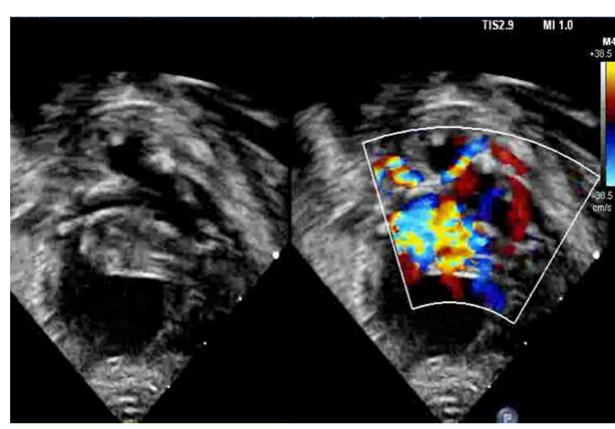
Initial transthoracic echo with concern for tortuous venous connection with intact atrial septum
